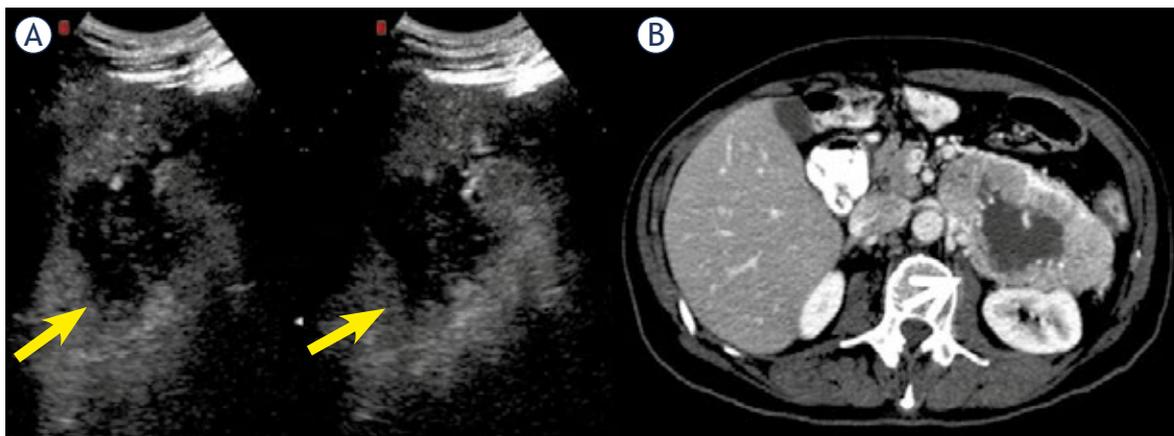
A 45 yrs old female: CEUS study of inhomogeneous pancreatic lesion (A), with necrotic central area (arrow). CT (B), during late arterial phase of contrast study shows the same vascular profile (arrow) seeing during CEUS study.
